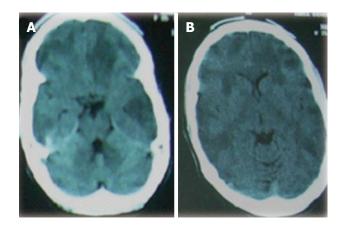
Cranial computed tomography brain showing axial views (A, B) with bilateral multifocal large hypodense lesions in the frontal, parietal, temporal and occipital lobes.
